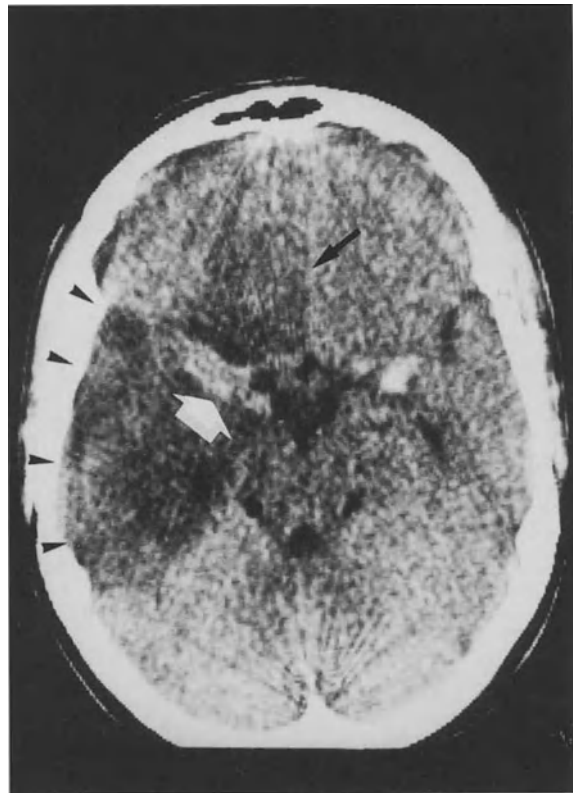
CT appearance of herpes simplex virus encephalitis in a non-HIV-infected patient. Hypodense areas can be seen in the right temporal lobe and frontobasal cortex. Note the typical hemorrhagic component, seen here as a hyperdense area in the right temporomesial region (*white arrow*)
